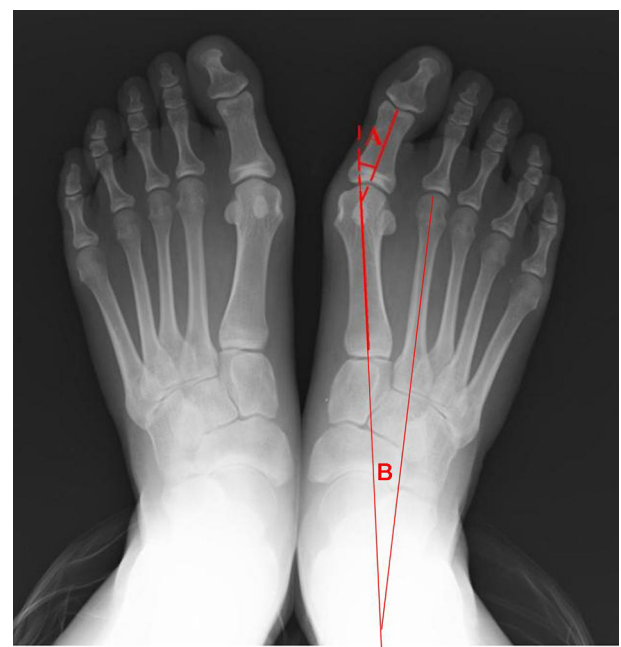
The preoperative X-ray shows the measurements of hallux valgus angle ($\angle A$) and 1–2 intermetatarsal angle ($\angle B$).
